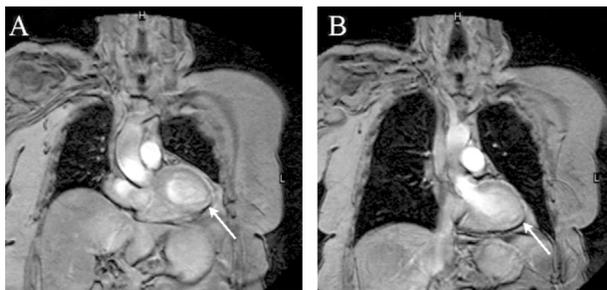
Effect of inspiratory breathholding on position of the heart relative to the left breast. These are coronal MR images of the thoracic cavity in a representative patient. (A) Image obtained at endtidal breathholding. Note that the apex of the left ventricle (arrow) lies in close proximity to the left breast. (B) Image taken at deep inspiratory breathholding. The diaphragm is pulled inferiorly, the lungs are expanded and the apex of the heart (arrow) moves away from the chest wall and left breast, as compared with the endtidal image.
